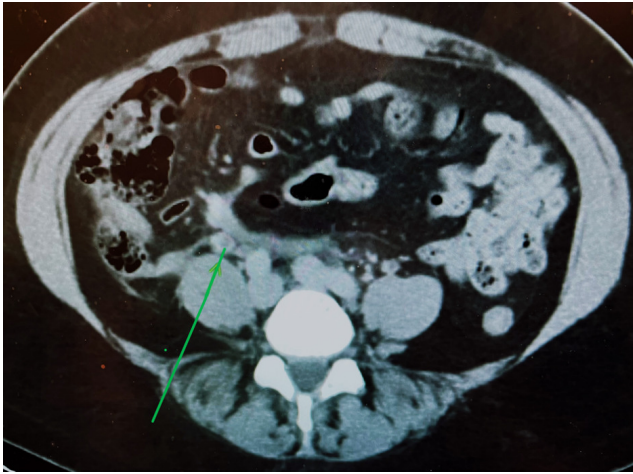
Partial Gonadal Vein thrombus seen (green arrow) on contrast enhanced abdominal/pelvic CT scan
